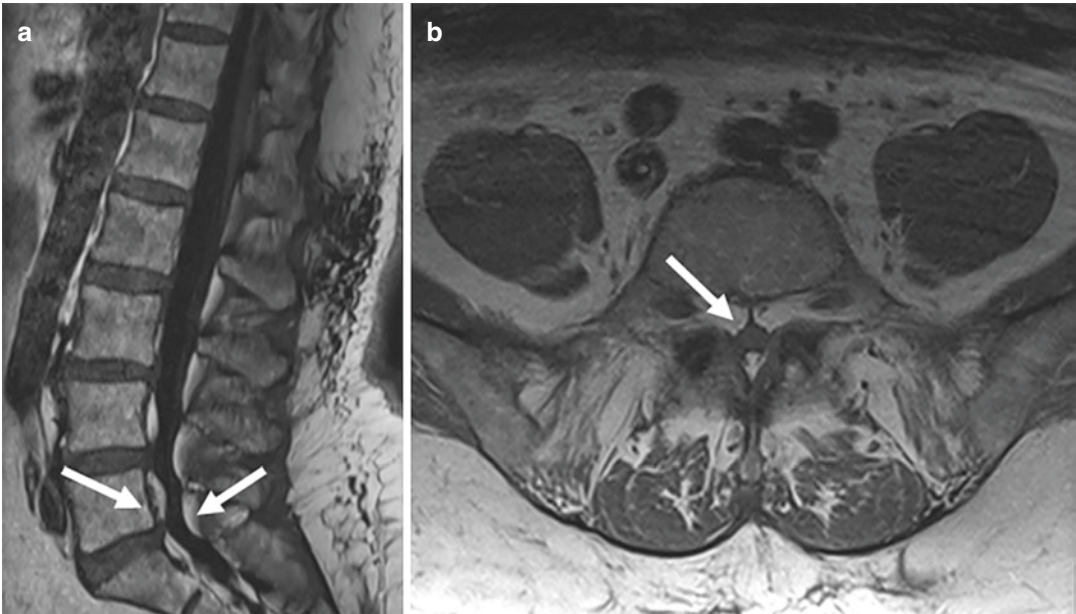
Spinal epidural lipomatosis. Sagittal (a) and axial (b) T1-weighted MRI of the lumbar spine demonstrates prominent epidural fat circumferentially narrowing the thecal sac (arrow)
